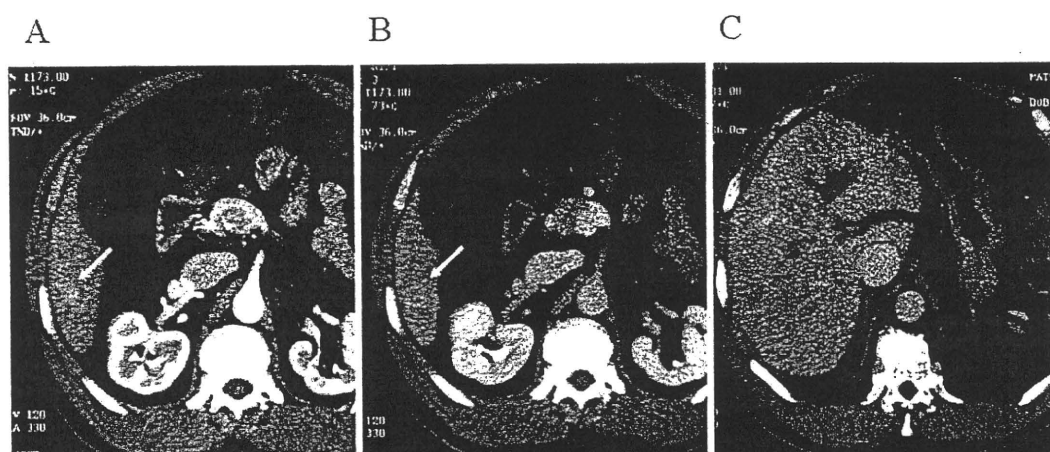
Abdominal computed tomography. A: The largest nodule showed contrast enhancement in the early phase (arrow). B: The largest nodule appeared isodense in the delayed phase (arrow). C: No portal flow is shown in the liver (delayed phase).
